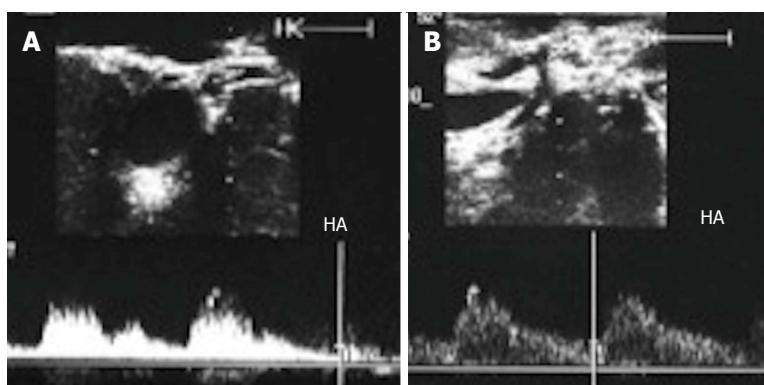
Gastroduodenal arterial steal. A: Intra-operative Doppler US image showing weak flow in the recipient HA (pre-anastomotic), with damped irregular systolic peak; B: Doppler US image after experimental clamping of the gastroduodenal artery, demonstrating improvement of the arterial waveform and regaining of the sharp systolic upstroke. Ligation of the gastroduodenal artery was then performed. HA: Hepatic artery.
